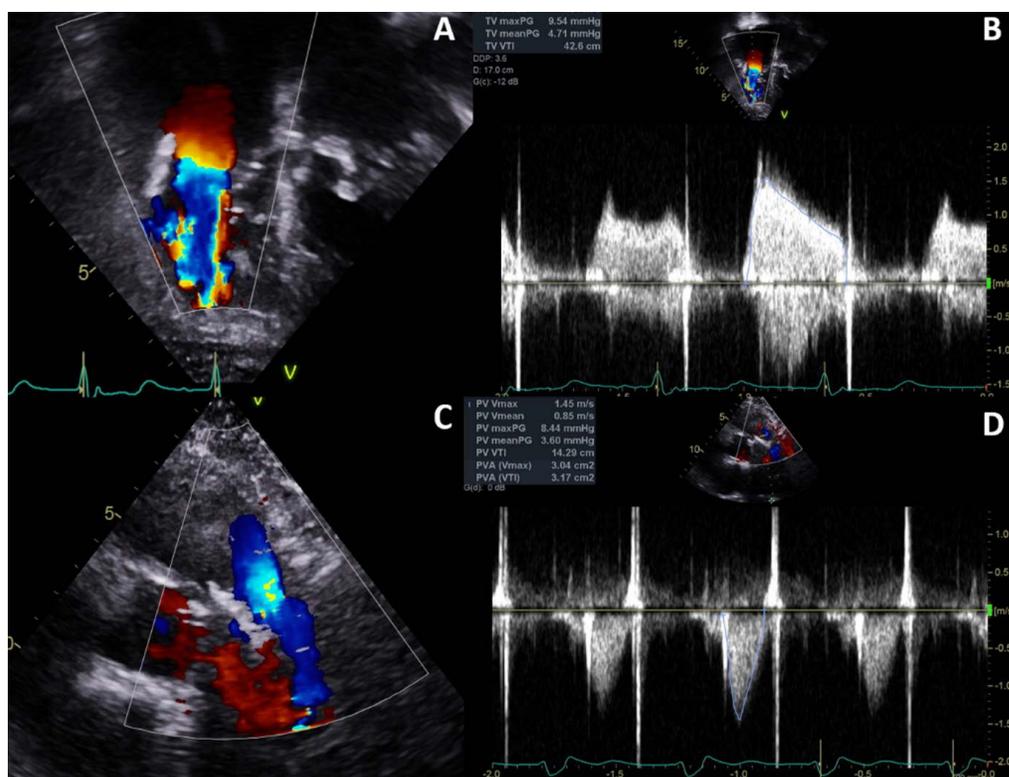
Post-intervention Outpatient Echocardiogram
